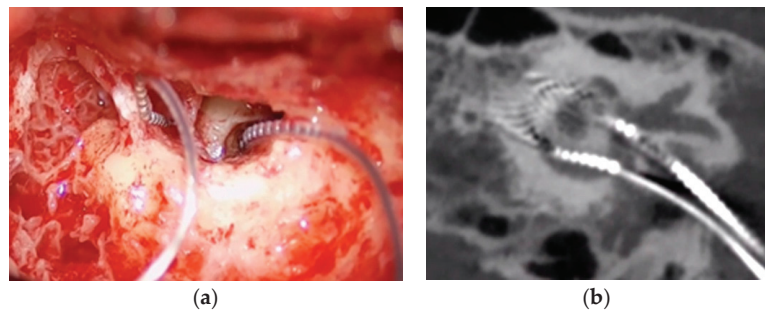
(a) Surgical image of electrodes' position; (b) CT postoperative electrode position.
